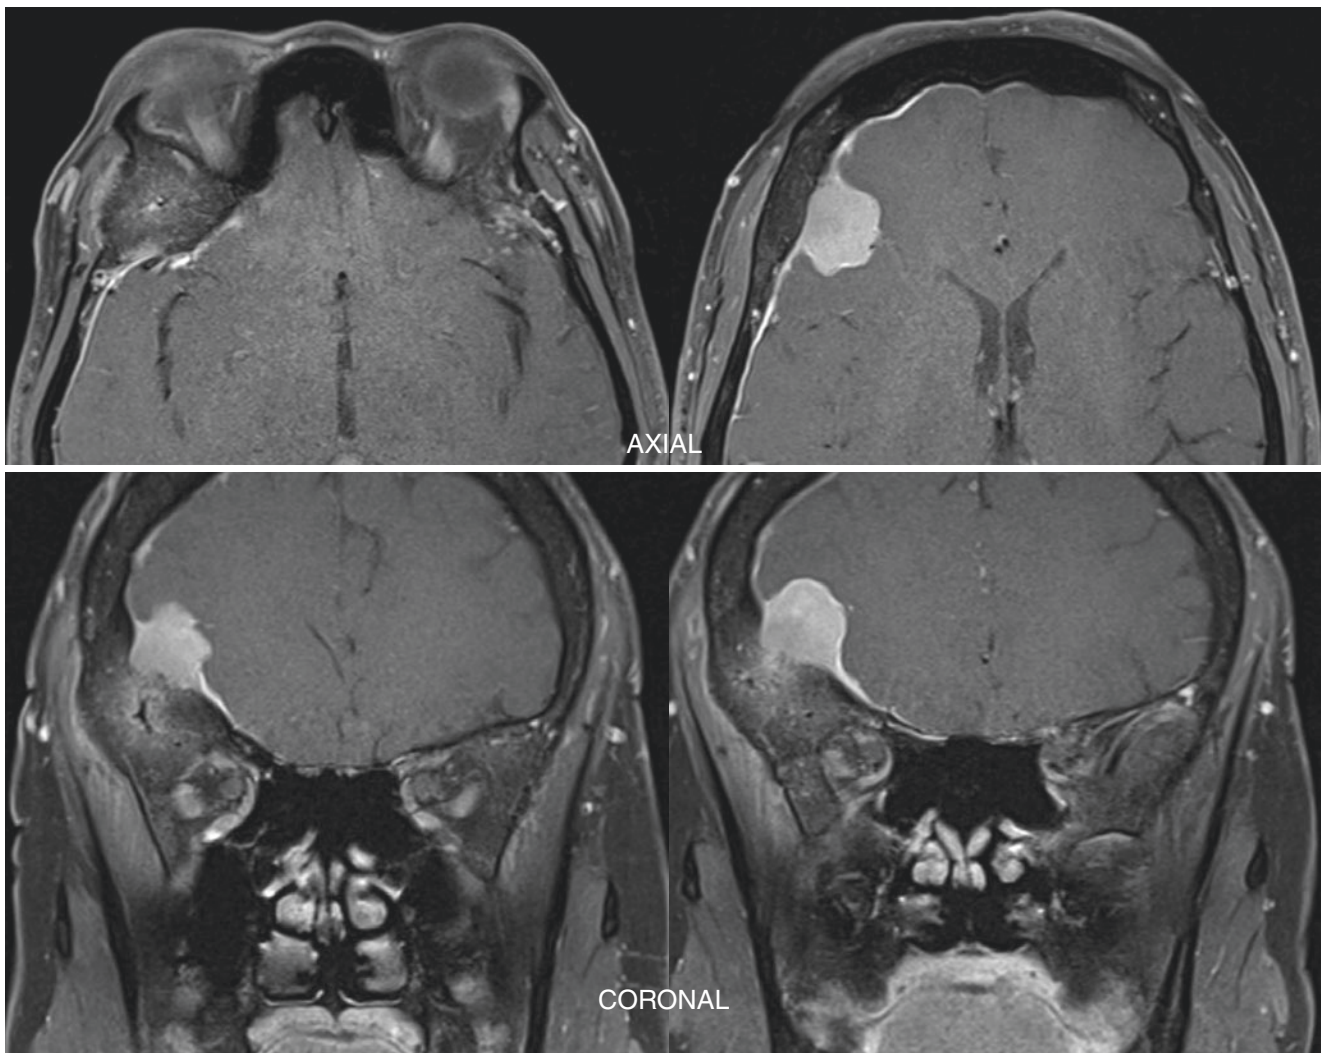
MRI of case 2: T1w-FS + C MRI shows an associated dural based intracranial soft tissue mass with enhancing dural tail
